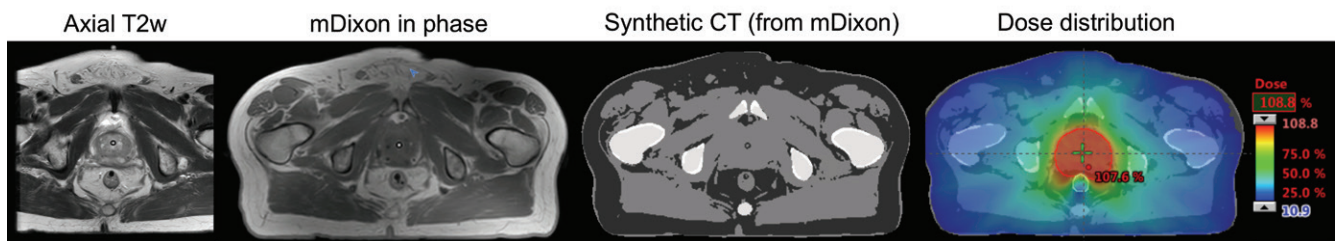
Offline MRI-guided RT of a patient with prostate cancer. The axial T2-weighted (T2w) image is used for diagnostic purposes, and the modified Dixon (mDixon) in-phase image is used for treatment planning. A synthetic CT image is created with an artificial intelligence algorithm from the mDixon image and is then used to compute the dose distribution. Figure adapted, with permission, from Dr Neelam Tyagi, Memorial Sloan-Kettering Cancer Center.
